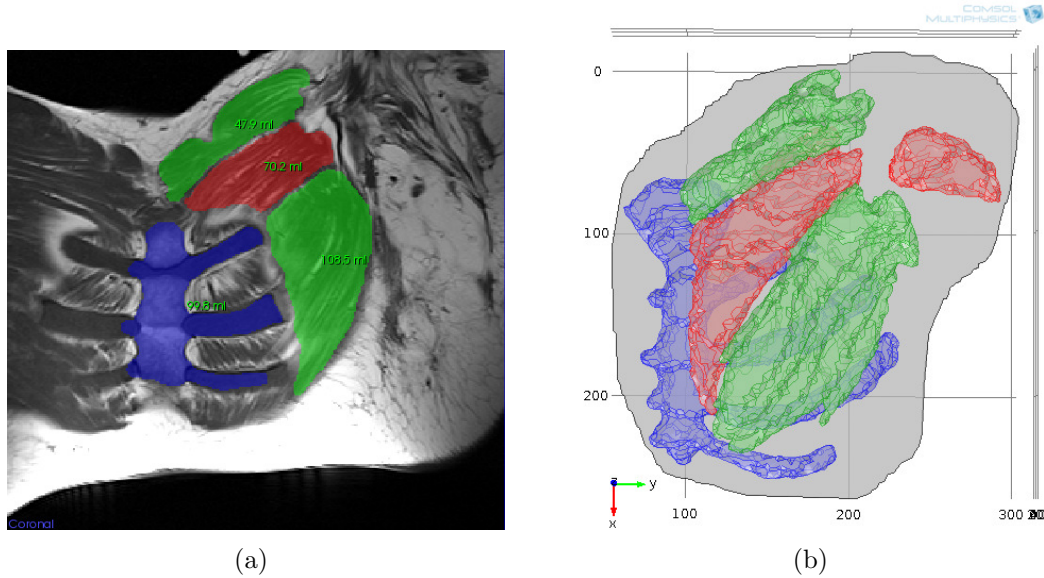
Three dimensional generic EMG model using FEA. (a) Segmented magnetic resonance image of the torso of a TMR patient in the coronal plane. One can see the sternum and the ribs, and the three segmented parts of the musculus pectoralis major. (b) Three dimensional model of the chest of a TMR patient, which is generated from the set of segmented images.
